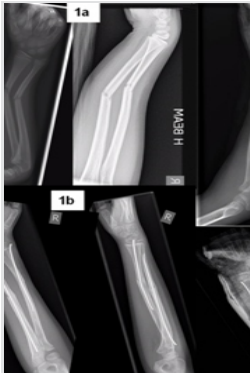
(a) X-ray of the right forearm at initial presentation $t=0$. (b) X-rays at planned follow-up 4 months later, $t=4/12$.
